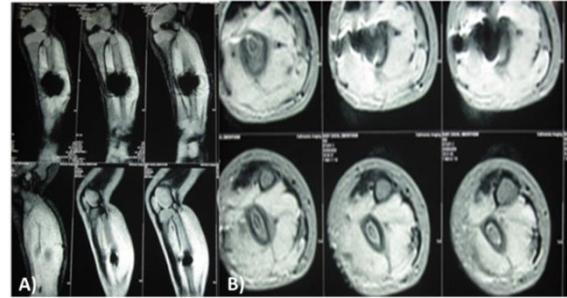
MRI of the right leg during active stage of disease, A) T1W MRI, coronal section showing enlargement of shaft of fibula with periosteal reaction and formation of new bone without marrow signal changes, B) Axial section showing the same changes
